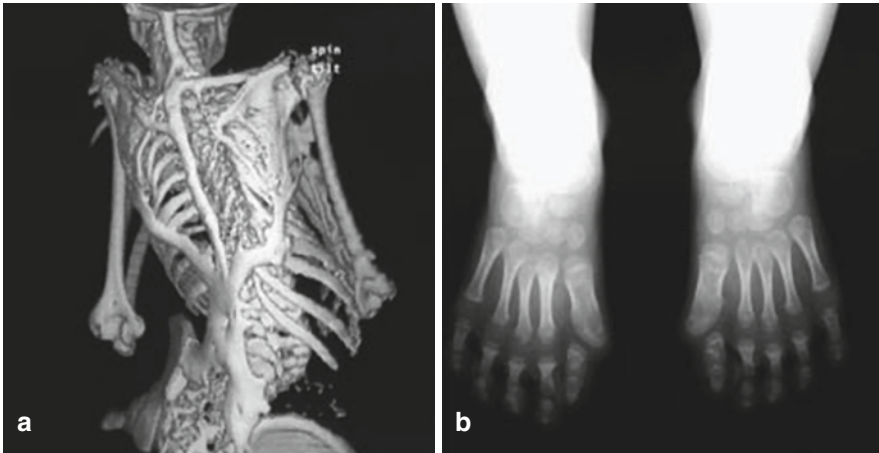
Characteristic clinical features of FOP. (a) Extensive heterotopic bone formation typical of FOP as seen in a three-dimensional reconstructed computed tomography (CT) scan of the back of a 12-year-old child. (b) Anteroposterior radiograph of the feet of a 3-year-old child that shows symmetrical great toe malformations (source: Shore et al. [91]. Copyright held by the authors).
